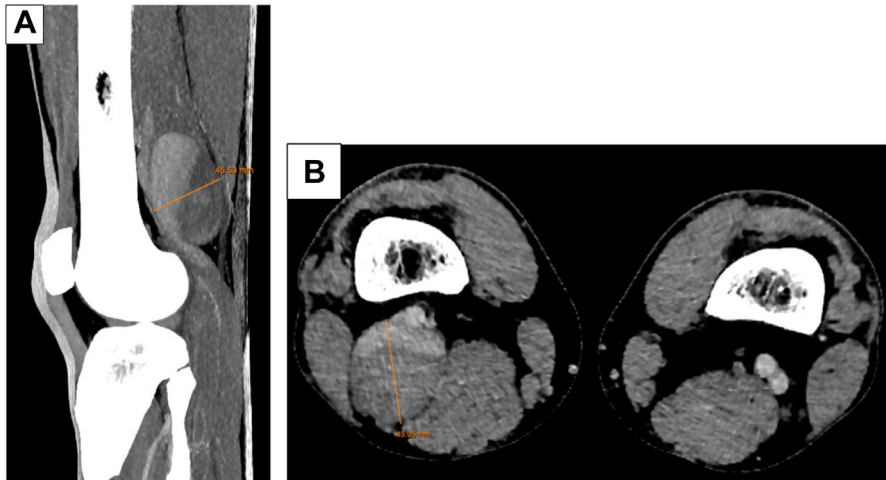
(A) CT angiography of the left popliteal region with delayed phase imaging: Sagittal view of a 45 mm venous aneurysm. (B) CT angiography of the left popliteal region with delayed phase imaging: Axial view of a 45 mm venous aneurysm.
